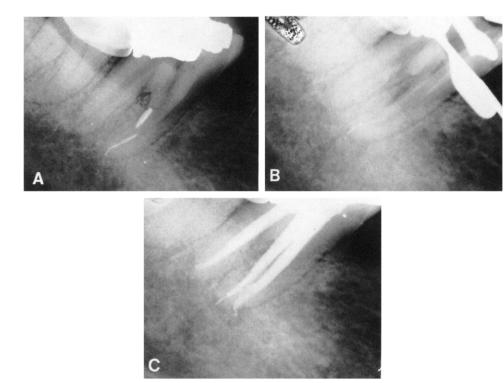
Case 5. A, Preoperative radiograph revealing a broken bur and some file segments. B, Bur and a file segment removed with endosonics. C, Postobturation radiograph.
